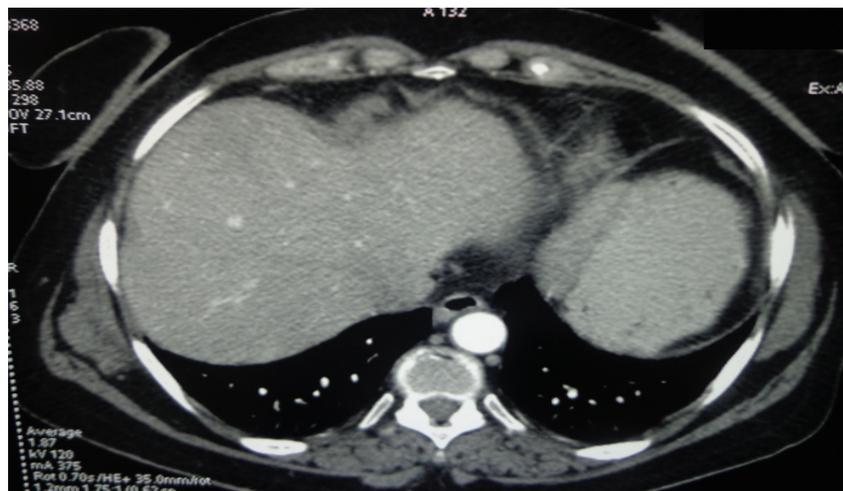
Axial view of abdominal high resolution CT-scan without anomalies.
